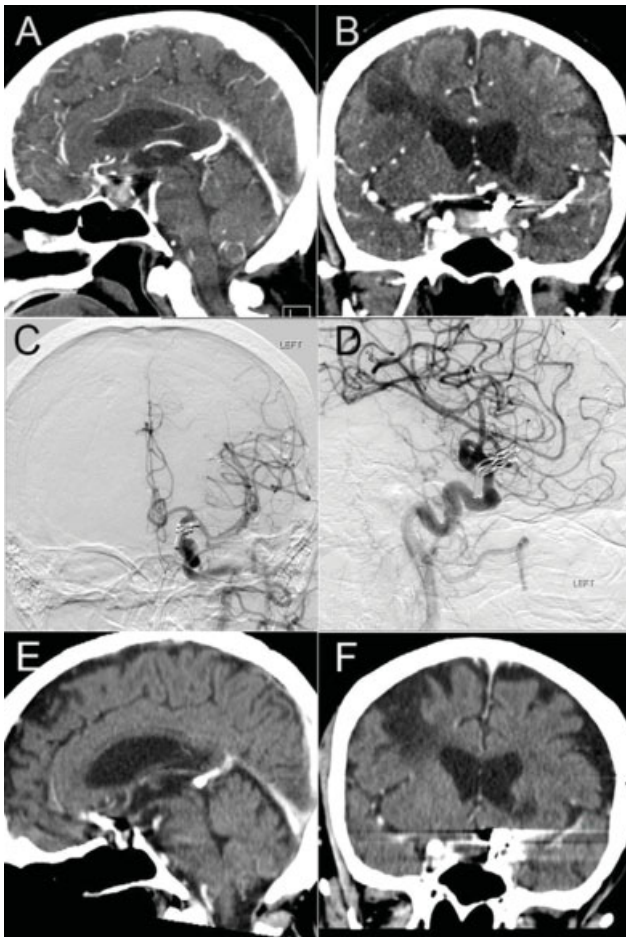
CT scans sagittal (A) and coronal (B) sections showing hyperdense sellar lesions in close proximity to an aneurysm
